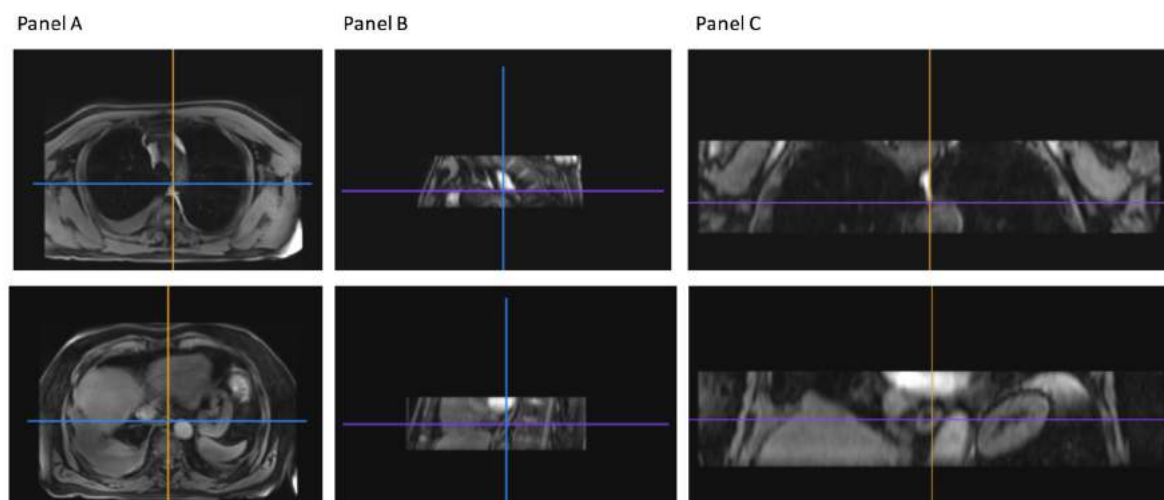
Example of a non-contrast enhanced MRI scan, acquired in separate axial blocks (Panel A) and their corresponding sagittal (Panel B) and coronal (Panel C) images, early in the process of developing imaging protocols for the Early Contrast Enhancement study
